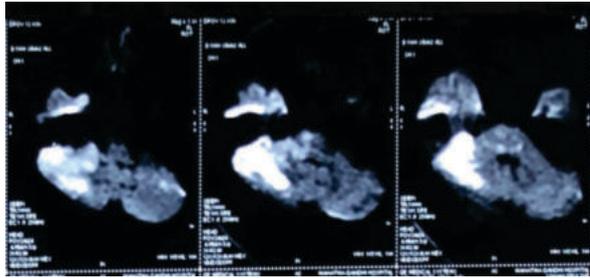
DWI section of noncontrast MRI
